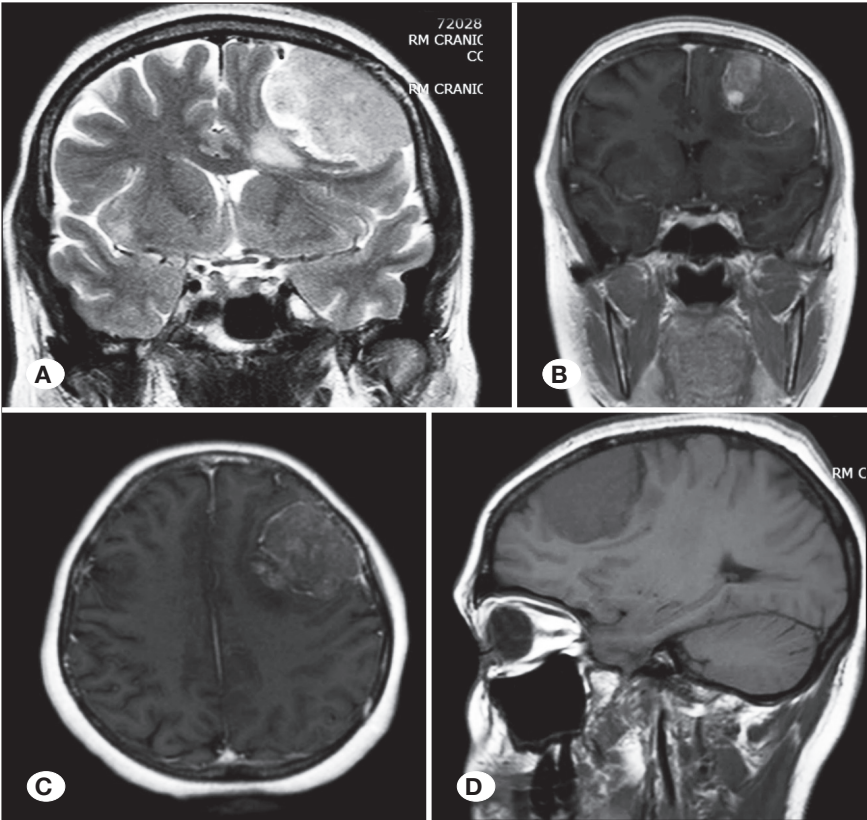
Preoperative magnetic resonance imaging (MRIs). A) Coronal T2-weighted MRI showing an isointense lesion. B) Coronal post contrast-enhanced T1-weighted MRI showing a heterogeneous contrast uptake. C) Axial post contrast-enhanced T1-weighted image. D) Sagittal T1 -weighted MRI showing an isointense lesion.
